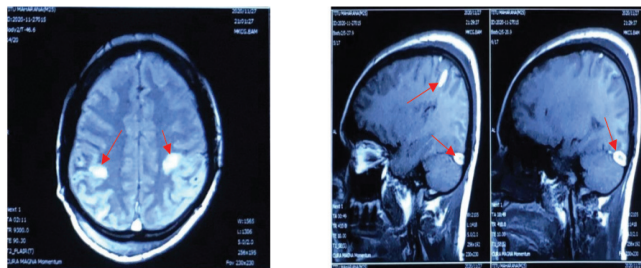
MRI brain showing multifocal hemorrhages involving both parietal lobe and occipital lobe. (red arrows)
